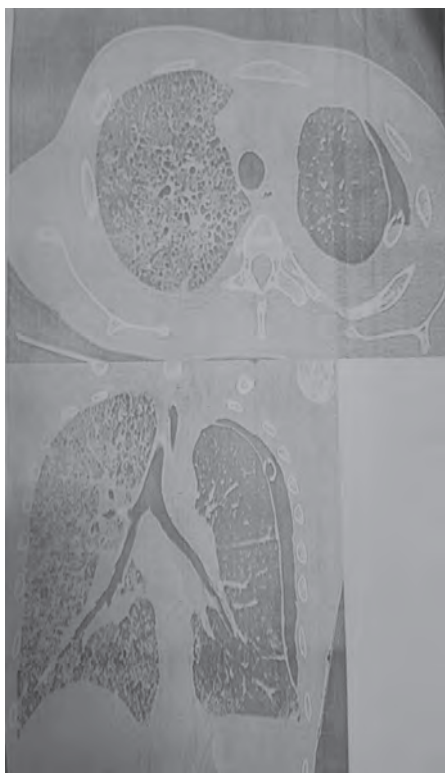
Chest radiographs and CT chest showing the pulmonary and pleural abnormalities at presentation
